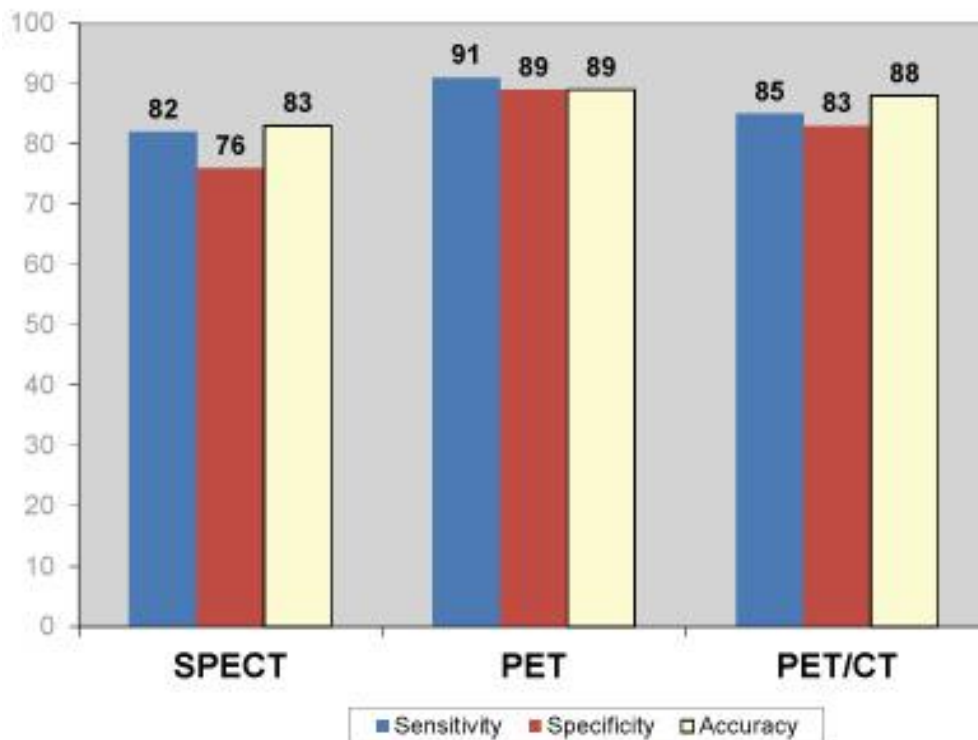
Overall pooled mean diagnostic values of SPECT, PET and PET/CT for detection of coronary artery disease.
